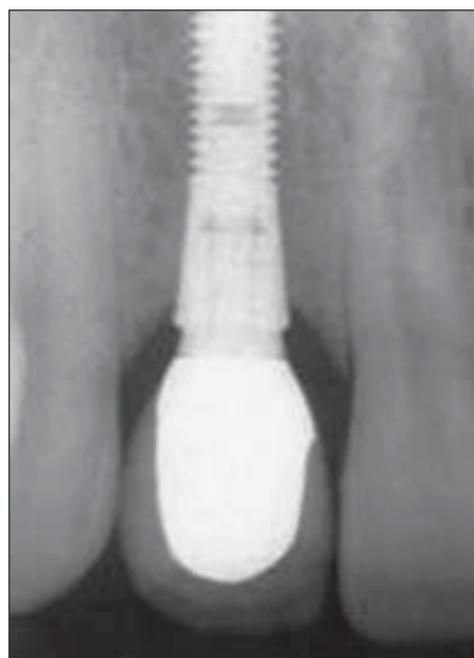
Intraoral periapical radiograph displaying the implant placed at the site of 11, and its relation to adjacent structures
